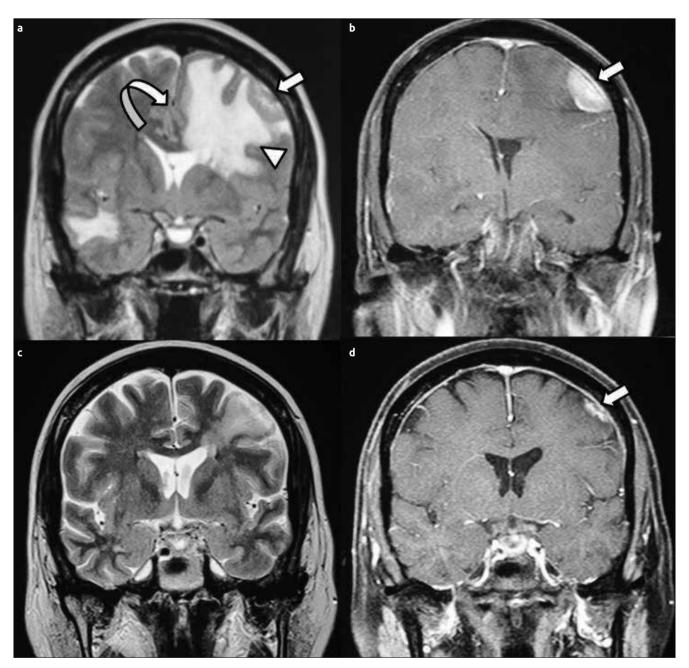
a-d. Coronal T2-weighted MR image shows dural metastases (arrow) adjacent to the left frontal lobe and surrounding edema (arrow head). Note that the edema causes midline shift effect (curved arrow) (a). Contrast-enhanced coronal T1- weighted MR image shows homogenously enhancing dural-based mass (arrow) (b). Coronal T2- weighted MR image obtained after radiotherapy and lapatinib based therapy show regression of the surrounding edema and normalization of the midline (c). Contrast-enhanced coronal T1- weighted MR image obtained after treatment shows regression in size of the dural-based mass (arrow) (d)
